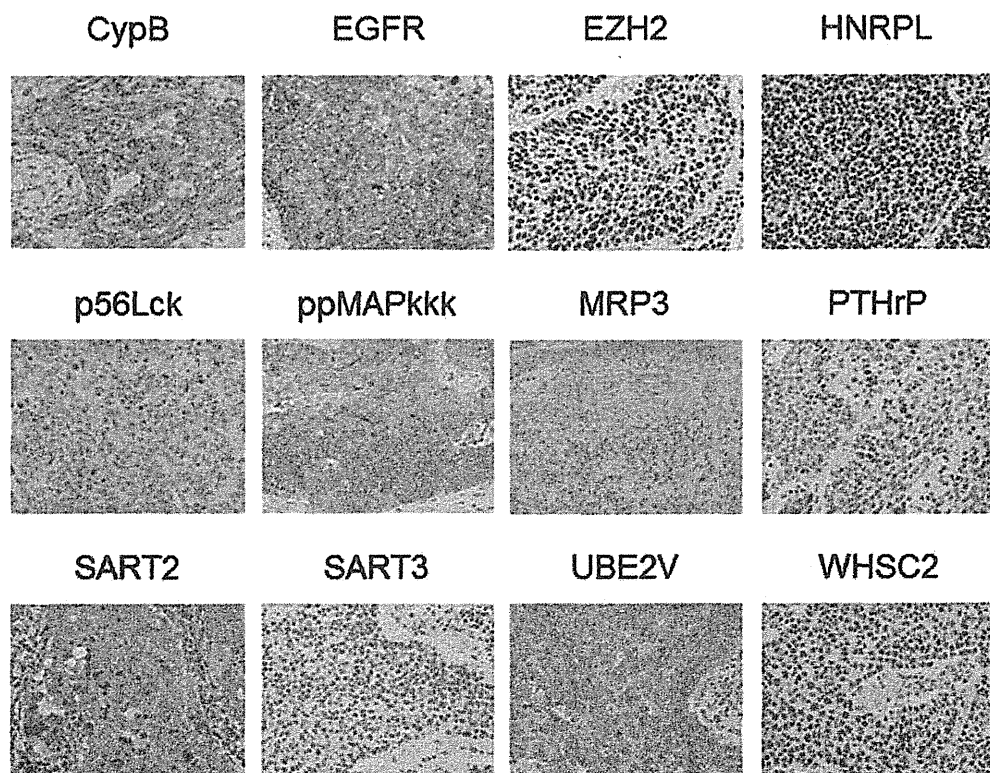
Expressions of vaccine antigen in lung SCC tissues. Expression of 12 vaccine antigens, from which the peptides were derived, was examined by IHC in primary cancer tissues of 10 non-vaccinated lung SCC patients. Representative results are shown (x400). The data of three prostate-related antigens, PAP, PSA and PSMA, are not shown.
